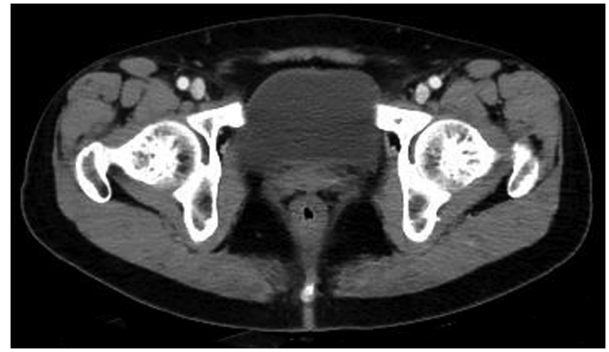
Computed tomography image of normal bladder.
